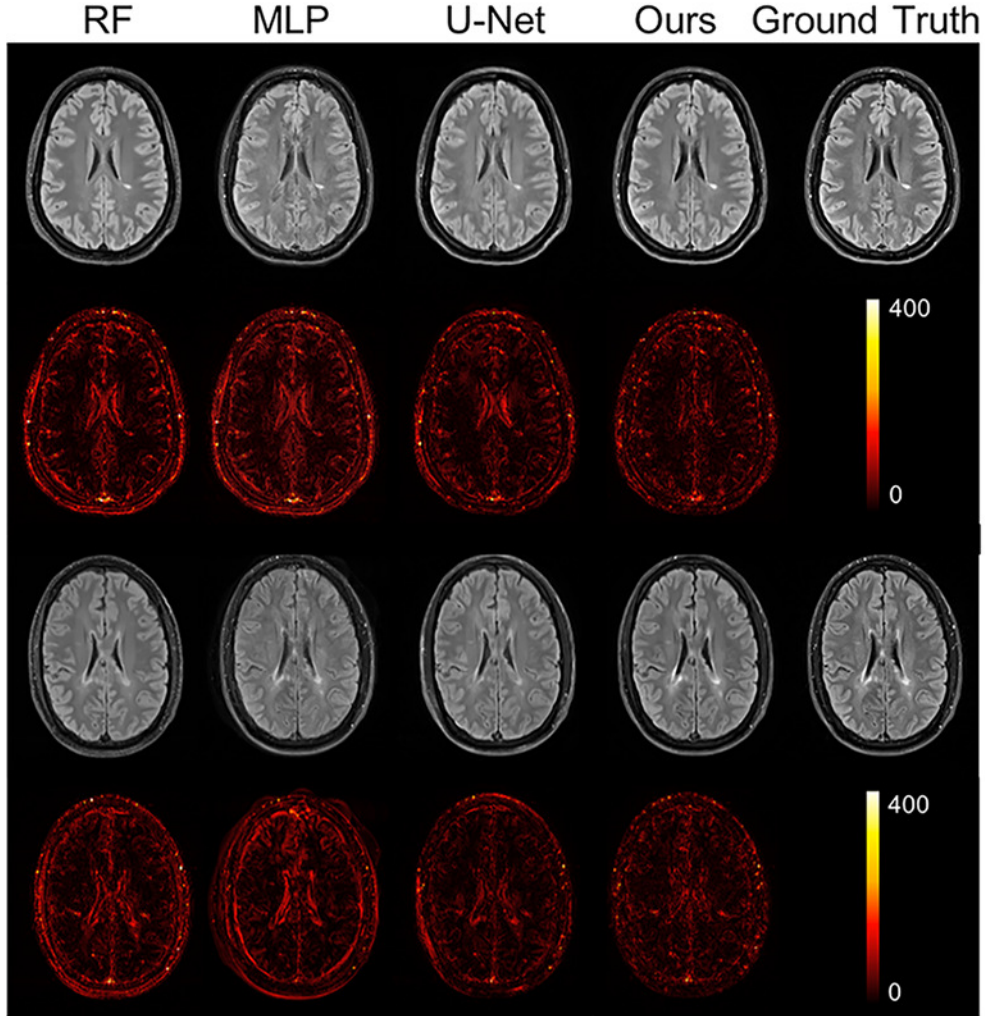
Qualitative comparison of the methods to predict FLAIR sequence.
